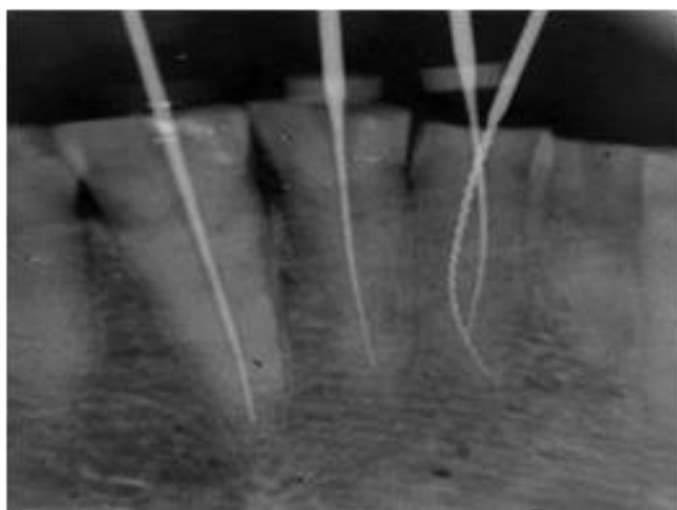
Working Length radiograph of 31,32,33
